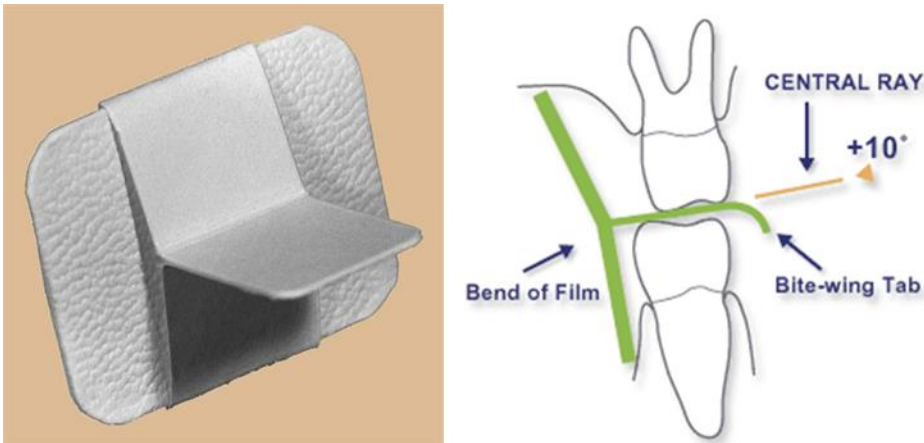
Left, paper loop placed around a size 2 adult film to support the film when the patient bites on the tab for a bitewing projection. Right, bitewing technique.
